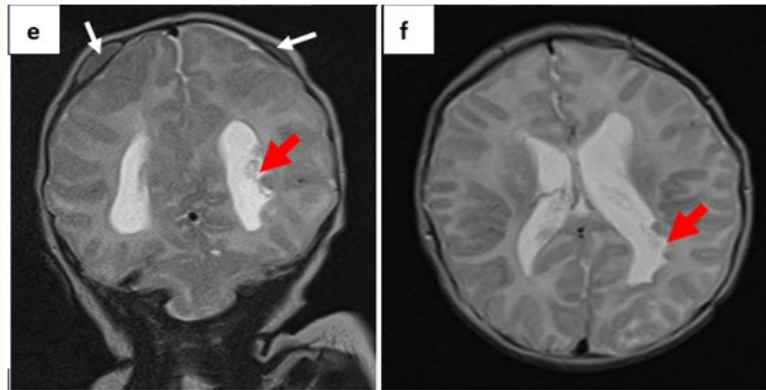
MRI appearance suggestive of an open lumbosacral myelomeningocele (a) associated with an occipital encephalocele (b), cerebellar tonsil protrusion (c), syringomyelia cavity at the terminal filum level with a low-lying spinal cord at L3 (d), nodular heterotopia gyration abnormality (e, f).
